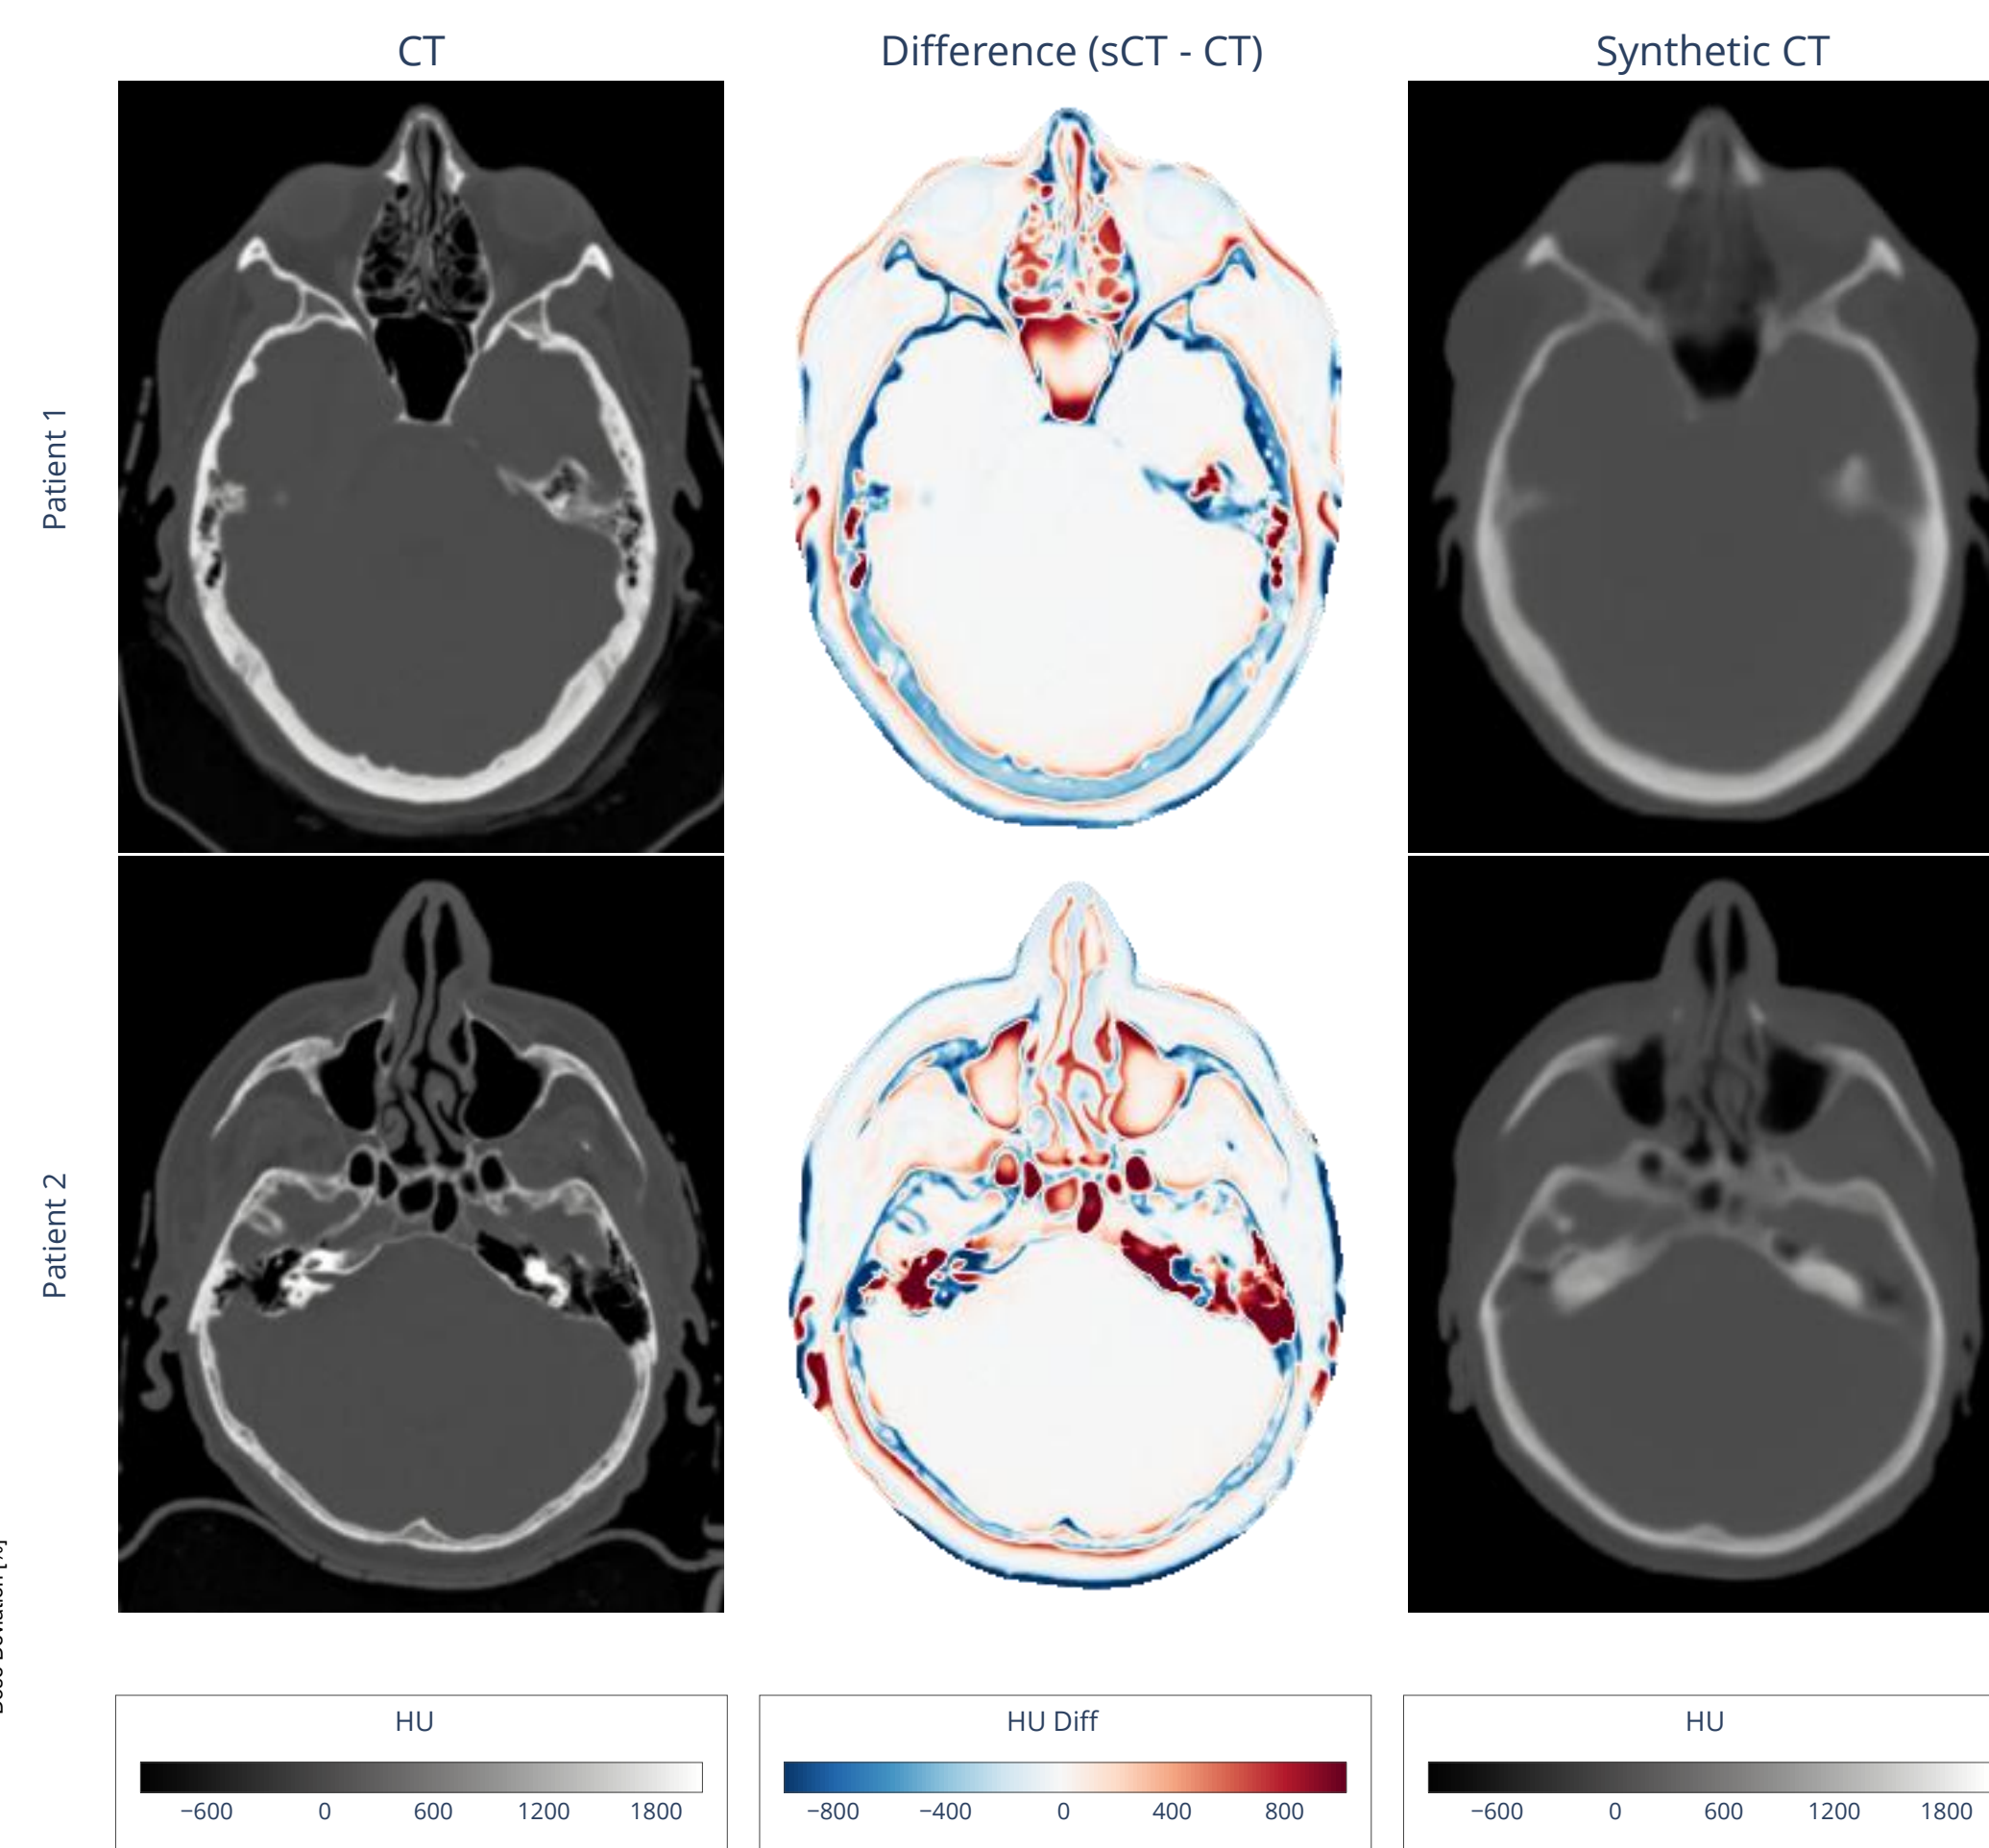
Qualitative comparison showing the reference CT, difference map, and deep-learning synthetic CT for representative patients.
